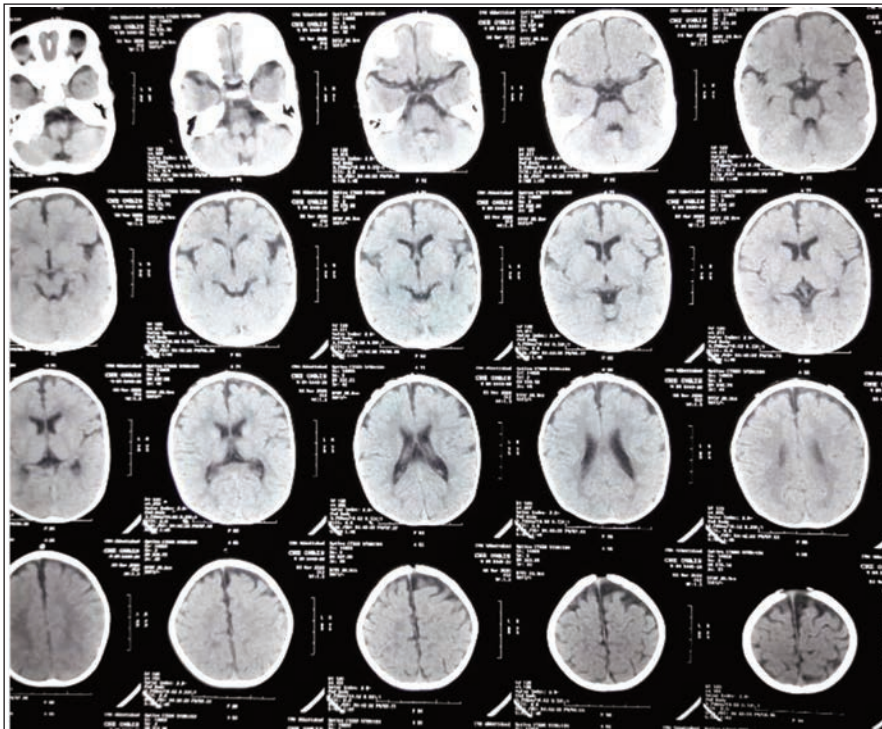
Plain CT scan of brain: Showing normal grey and white matter interface with mild frontal lobe atrophy.
